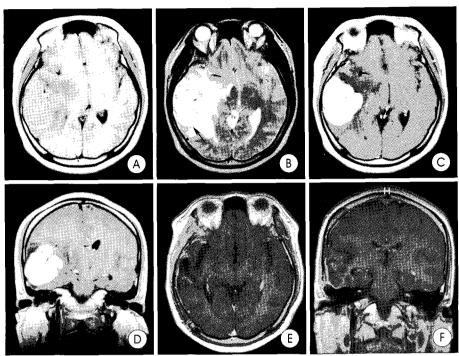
A: T1—weighted magnetic resonance imaging showing a mass lesion isointense to gray matter in the right temporal lobe. B: T2—weighted axial magnetic resonance imaging showing the heterogenous bubbly appearance of the posterolateral portion of the lesion, and marked peritumoral hyperintensity. C, D: Axial and coronal postcontrast magnetic resonance imaging revealing intense, relatively homogenous enhancement of the lesion. D, E: Axial and coronal postcontrast magnetic resonance imaging obtained 10 months after operation showing no evidence of recurrence.
